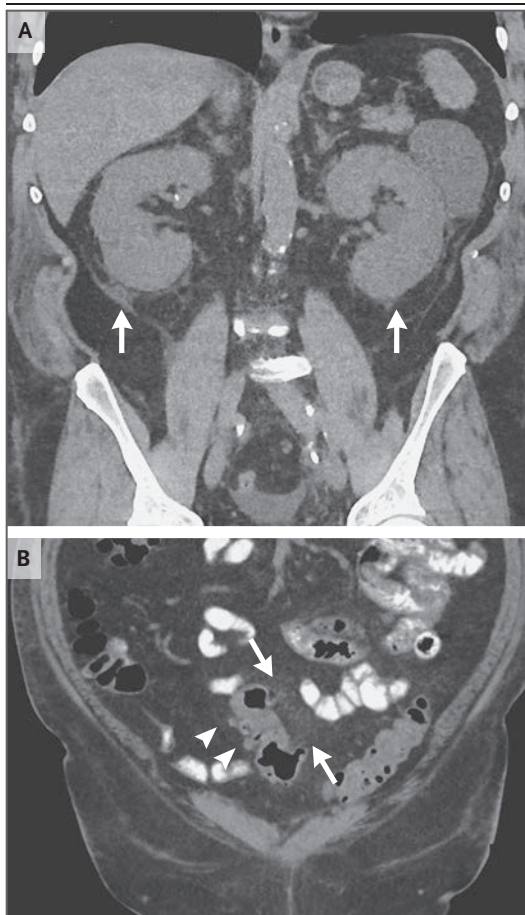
CT Scan of the Abdomen and Pelvis.
